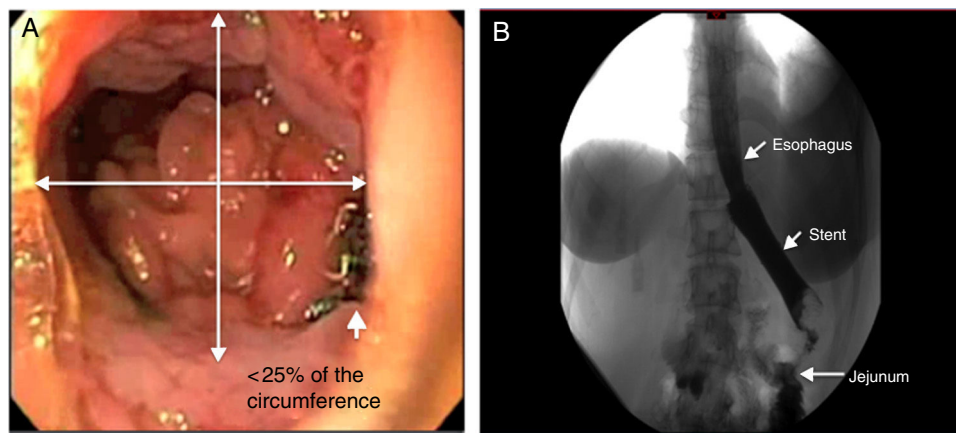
A) The endoscopic image shows the leakage site. B) The x-ray shows the esophageal stent with no contrast agent leakage.
